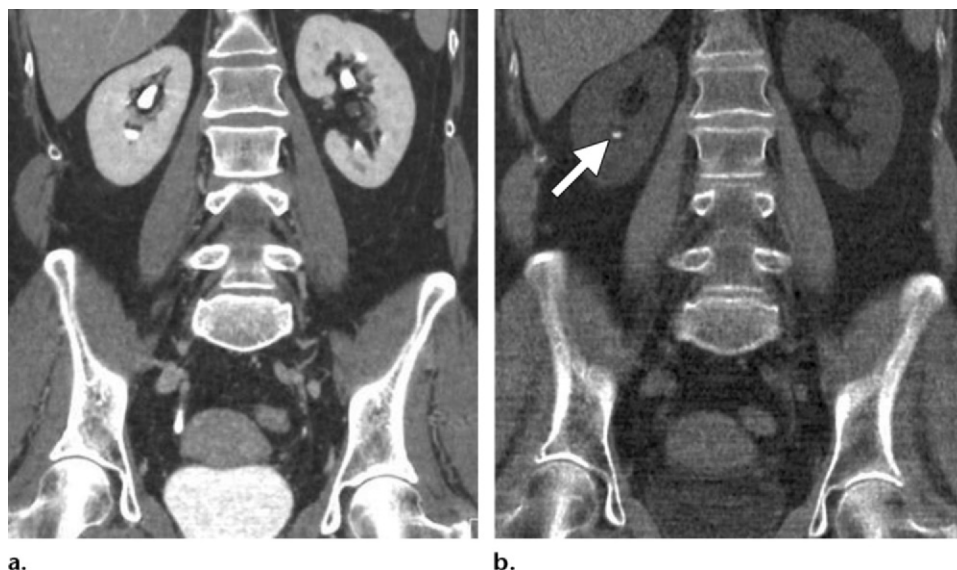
(a) Coronal excretory-phase image from dual-energy CT urography demonstrates contrast material in the renal collecting systems and bladder. (b) Coronal water-density (virtual unenhanced) image obtained from the same dual-energy CT image dataset as in a by subtracting all iodine-containing pixels from the renal collecting systems and bladder clearly depicts a 5-mm calculus (arrow) in the lower pole of the right kidney.
